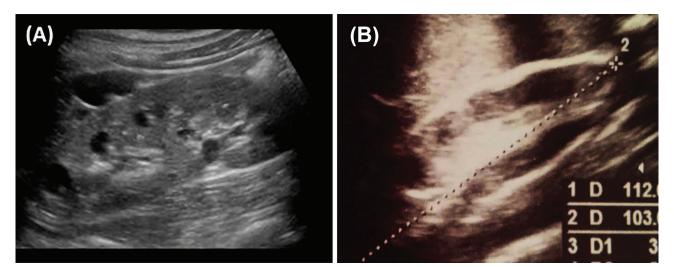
Ultrasonographic Images of the ADPKD (A) and Healthy Kidneys (B) [Abnormal enlargement of the kidneys and multiple cysts are obvious in the kidneys of ADPKD patients.]
